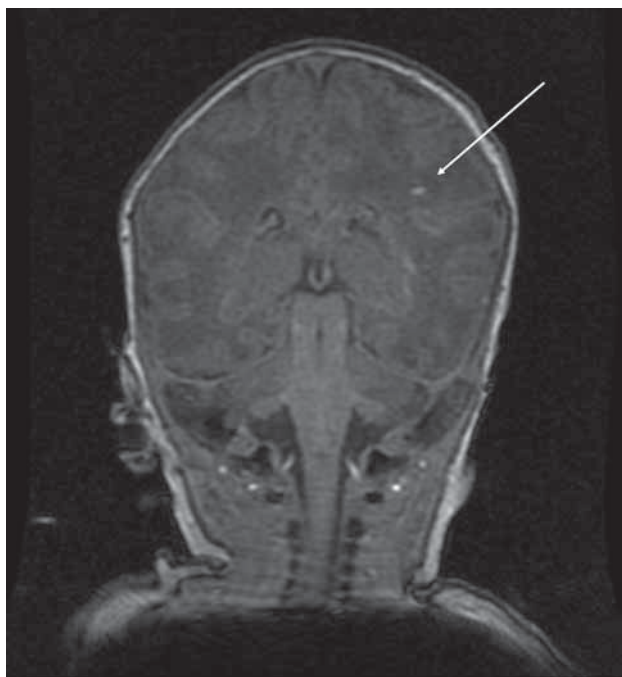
A solitary T1-weighted PWML was demonstrated in the left corona radiata of 1 study patient (white arrow).
